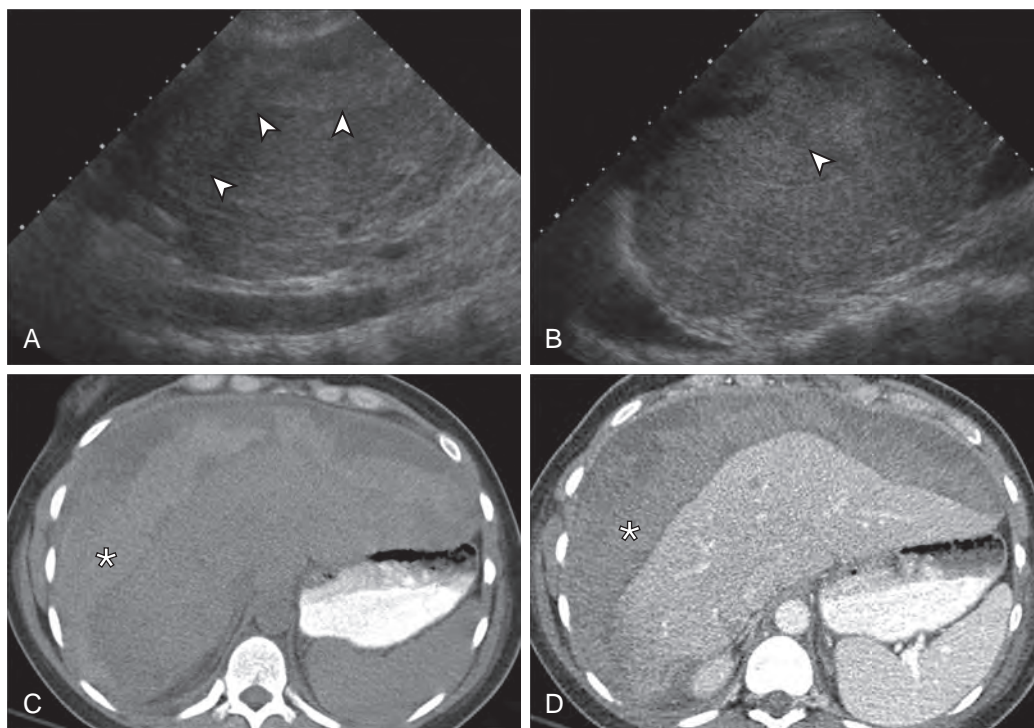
Subcapsular hematoma on ultrasound in a pregnant patient with HELLP syndrome. A. Extensive subcapsular hematoma is subtly delineated adjacent to the left lobe of the liver on this longitudinal ultrasound scan (arrowheads). B. Subcapsular hematoma is also seen adjacent to the right lobe of the liver (arrowhead). C. Noncontrast CT shows the corresponding CT appearance of sentinel clot in the subcapsular hematoma (asterisk). D. Contrast-enhanced CT also shows the subcapsular hematoma (asterisk).
